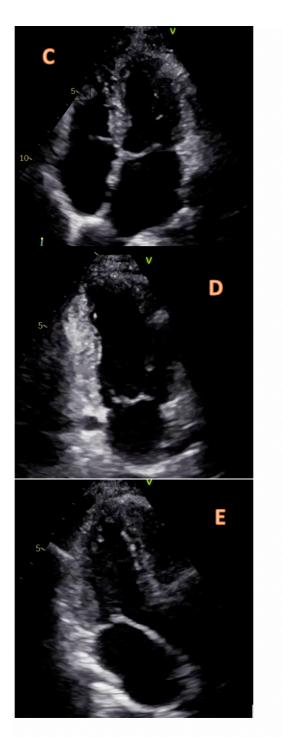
Apical 4 chamber (C), Apical 2 chamber (D) and Apical 3 chamber (E) views.
